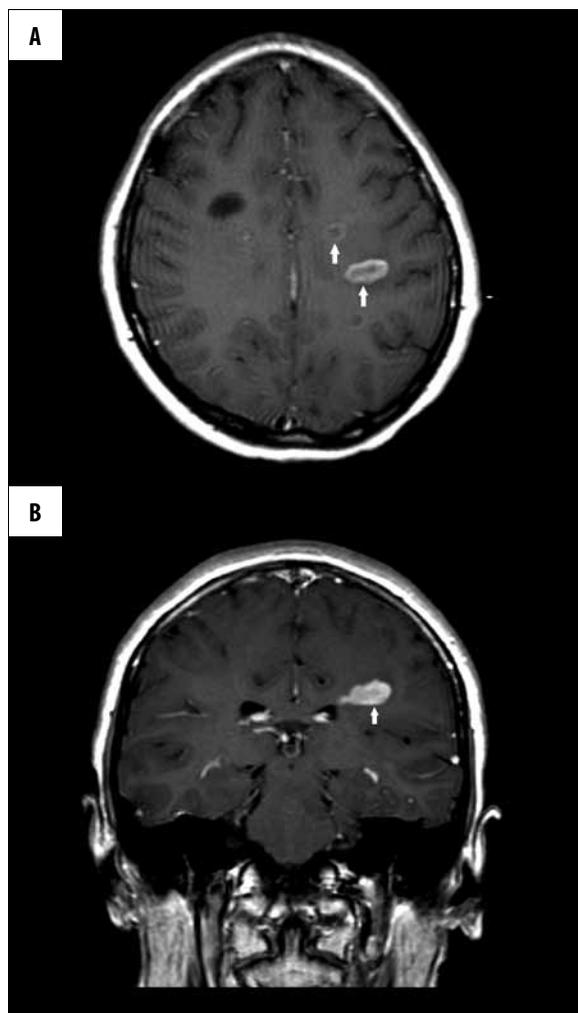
16-year-old girl, MRI brain scan. T1-weighted SE sequence image + CM: (A) transverse plane, (B) frontal plane. Foci of ring enhancement demyelinating changes in circumventricular white matter of left parietal lobe (arrows).
